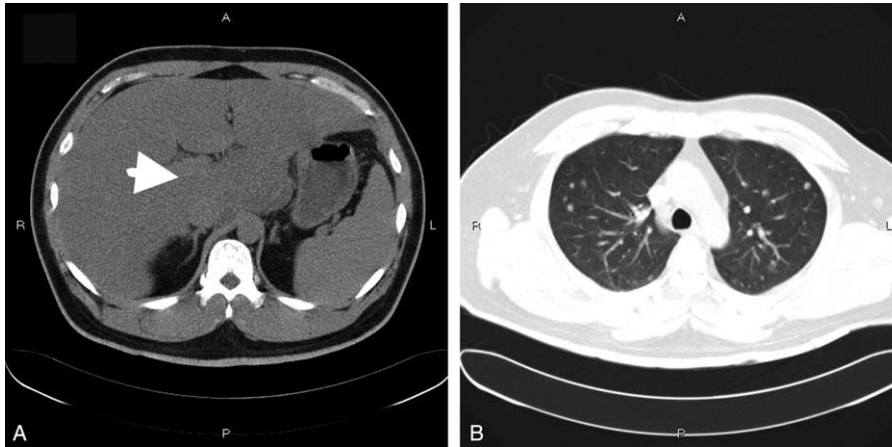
Noncontrast computed tomography showing (A) uneven fatty liver and an isodense hepatic tumor, measuring around 5.5 cm in size (arrow head) in hepatic caudate lobe with regional nodal metastases and (B) multiple lung nodules.
